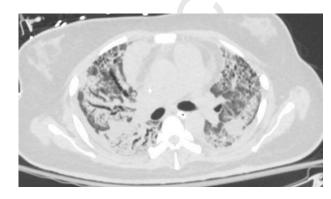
Case 2: CT chest with upper lobe predominant pulmonary fibrosis and traction bronchiectasis along with areas of ground-glass opacities.
